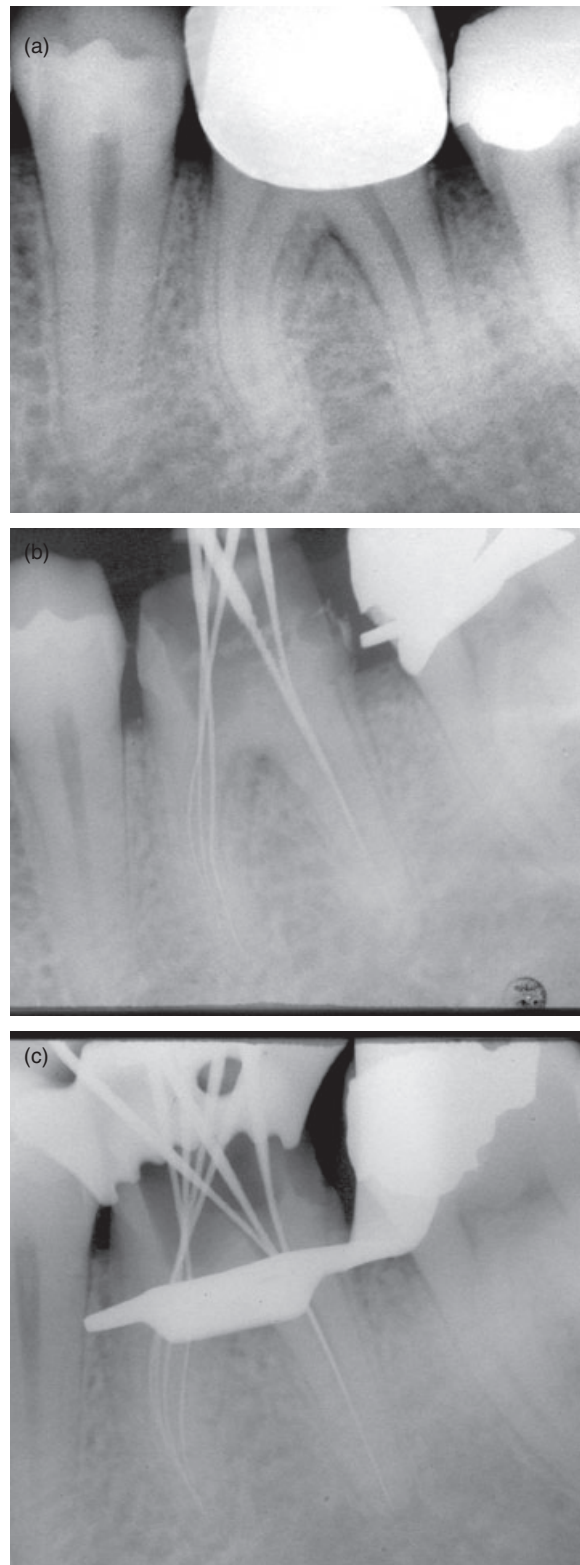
(a) Preoperative radiograph. (b) Initial working length radiograph with five endodontic files in place (three in the mesial root). (c) Second working length radiograph with seven endodontic files in place (four in the mesial root).
